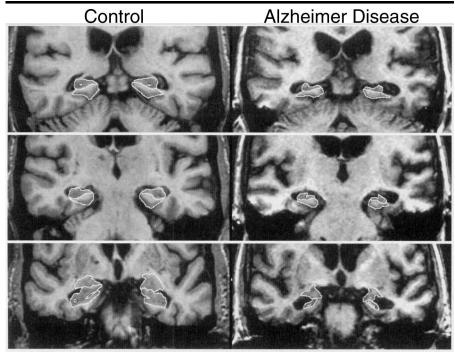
Coronal T1-weighted MR images demonstrate tracings of the hippocampus and parahippocampal gyrus in a 75-year-old female control subject (left) and 73-year-old woman with AD (right). Outlines of the amygdala and hippocampus are indicated in the bottom images.
